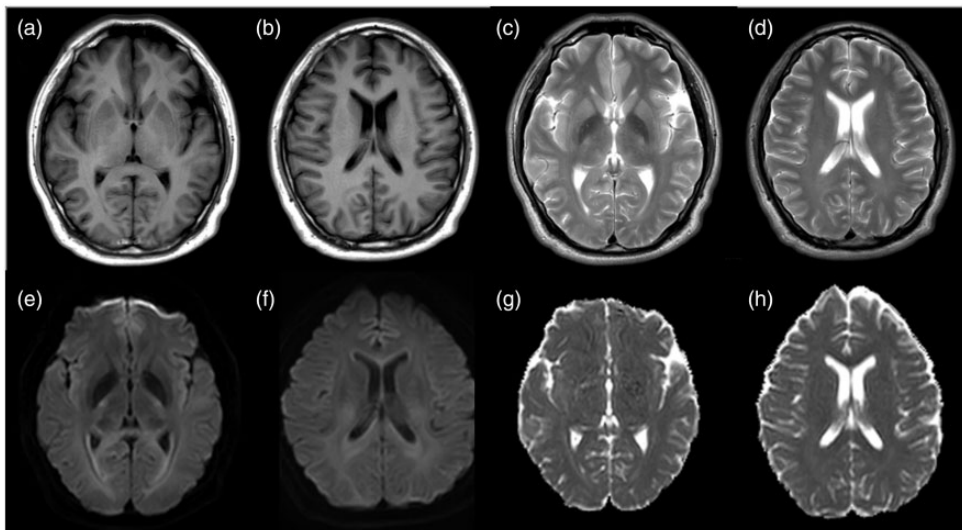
Magnetic resonance imaging of the patient (after 2 weeks of follow-up). Re-examination of brain magnetic resonance imaging showed that most of the lesions were reduced. (a,b) T1-weighted images. (c,d) T2-weighted images. (e,f) Regression of the lesion was visible on cross-section diffusion-weighted imaging. (g,h) Regression of the lesion was visible on cross-section apparent diffusion coefficient imaging.
